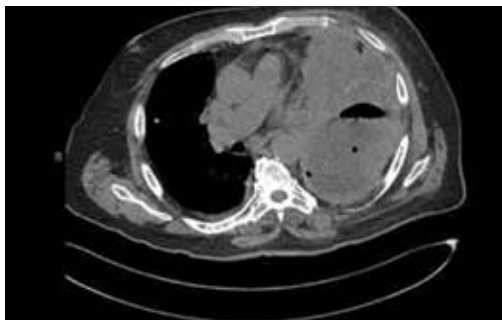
A repeat computed tomography revealed complicated parapneumonic effusion, an interval increase in complex left pleural air/fluid collection with persistent pleural rind, and consolidation of the left lung consistent with an underlying neoplasm.
